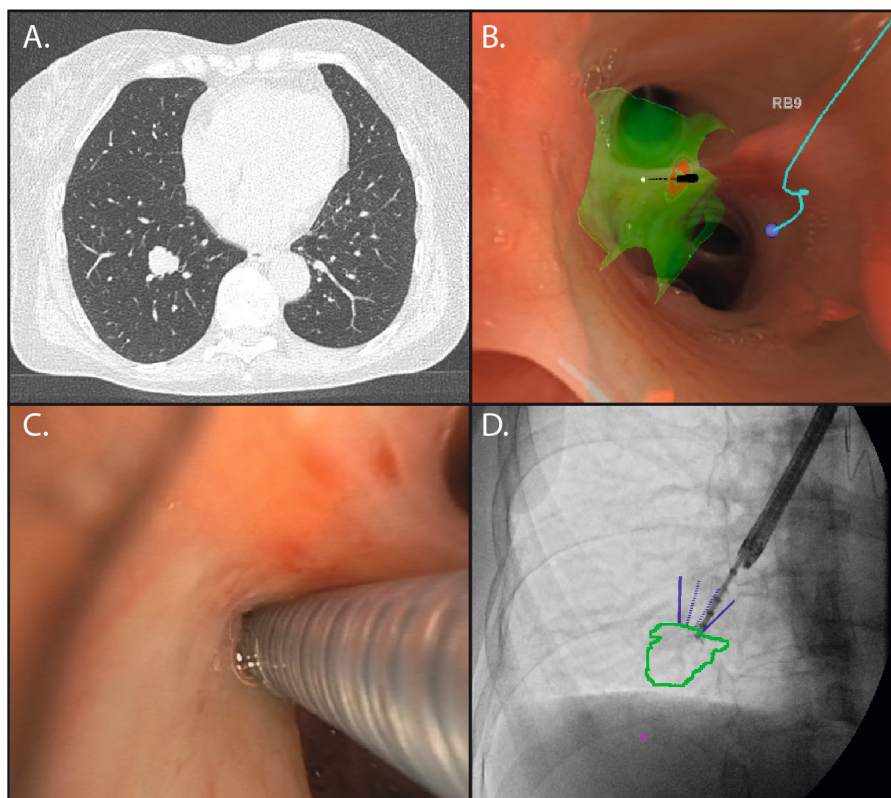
Procedure with a tunnel path. A. Solitary pulmonary nodule located in the right lower lobe (RB9), axial view on CT scan. B. Endoscopic view of RB9 with virtual overlays of airway path (blue), the intrapulmonary nodule (green) and the vessel-free location for puncture. C. Needle in subcarina of RB9 to access the intrapulmonary nodule. D. Fluoroscopy view of bronchoscope and tunnel sheet guided in direction to the nodule (green) with open forceps.
